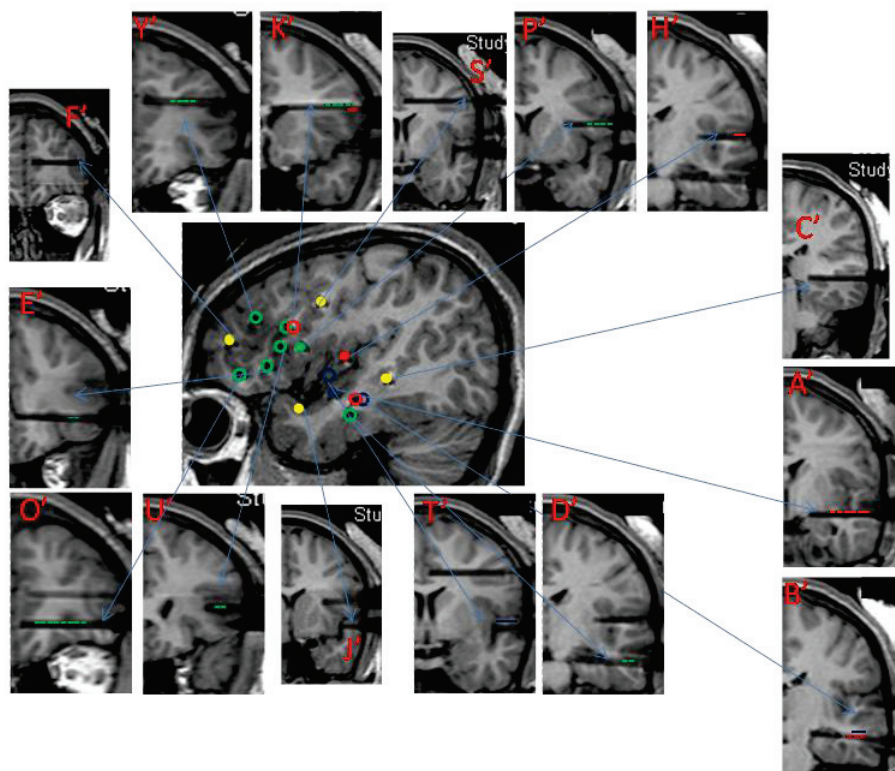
5: Patient 5 MRI with electrodes in place (Left hemisphere). Central sagittal image: each insular electrode is represented by a unique colored solid circle; non-insular electrodes are represented by empty circles with the color of each of the insular electrode they are responding to. Yellow solid circles are for non responding electrodes. Peripheral coronal images: a cross-section of each electrode with its name and its responding contacts (responses are indicated by color coded dotted lines, representing the color of the corresponding stimulated insular electrode).
